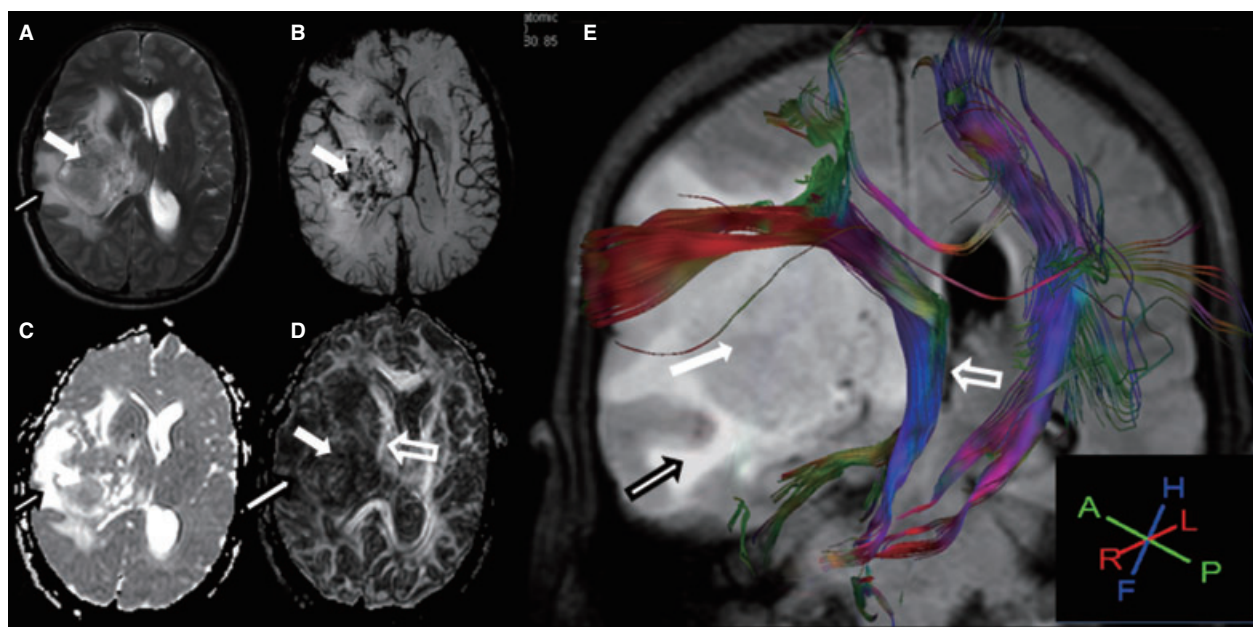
The potential pattern of a white matter (WM) fiber tract was altered by a gliosarcoma in a 57-year-old male patient. (A) Axial T2W shows that the gliosarcoma (white arrow) exerts a mass effect on the left temporal and insula lobe with surrounding hyperintensity vasogenic edema (black edge arrow). (B) Axial venous BOLD shows the diffuse hemosiderin (white arrow) inside the solid part of the tumor. (C) and (D) ADC and fractional anisotropy (FA) maps show the increased ADC and the decreased FA in the tract (hollow arrow) adjacent to the tumor. Diminished anisotropy was observed in the solid part of the tumor (darker region outlined on FA map) (white arrow). The boundary of the tumor identified in the FA maps was not as clear as that on the T2-weighted images because the anisotropy of the tumor was similar to that of the gray matter. (E) 3D tractography registered with FLAIR showed the ipsilateral corticospinal tracts and superior longitudinal fasciculus surrounding the surface of the tumor owing to mechanical compression. The WM tracts are deviated inferiorly by this gliosarcoma. The axial diffusivity, CI, and FA values in the ipsilateral corticospinal tract were reduced to 32%, 35%, and 28.7%, respectively, compared to the contralateral tract.
